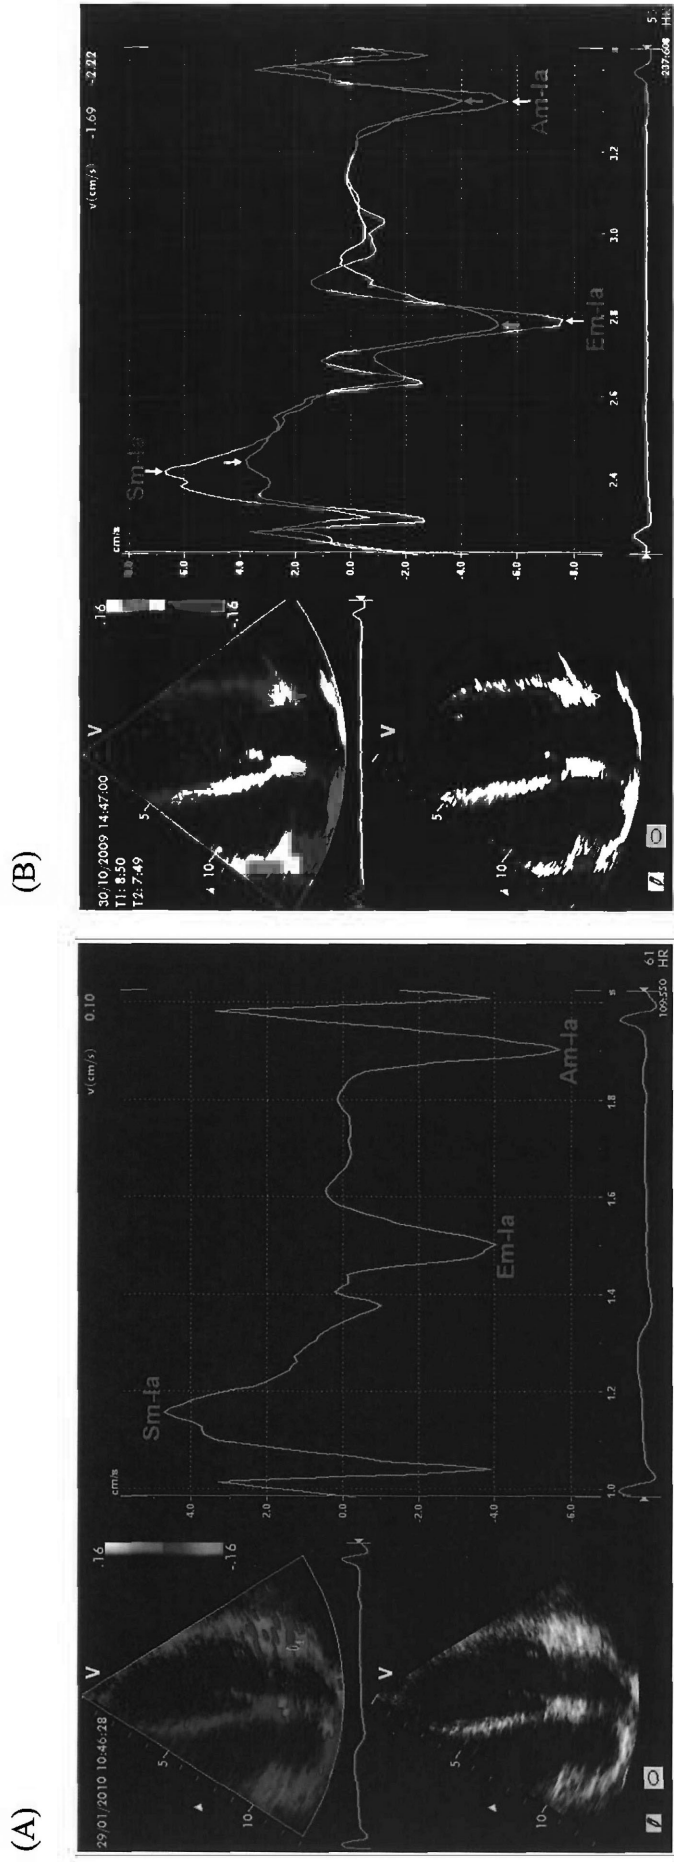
Longitudinal atrial velocities (Sm-la, Em-la and Am-la) from apical 4-chamber view using tissue Doppler imaging. A sample volume of 6 × 2 mm placed in mid-lateral of left atrium (LA). Sm-la is positive. Em-la and Am-la are negative velocities (A). In normal subjects, the values of atrial velocities are higher at lateral wall of LA than interatrial septum (B).
